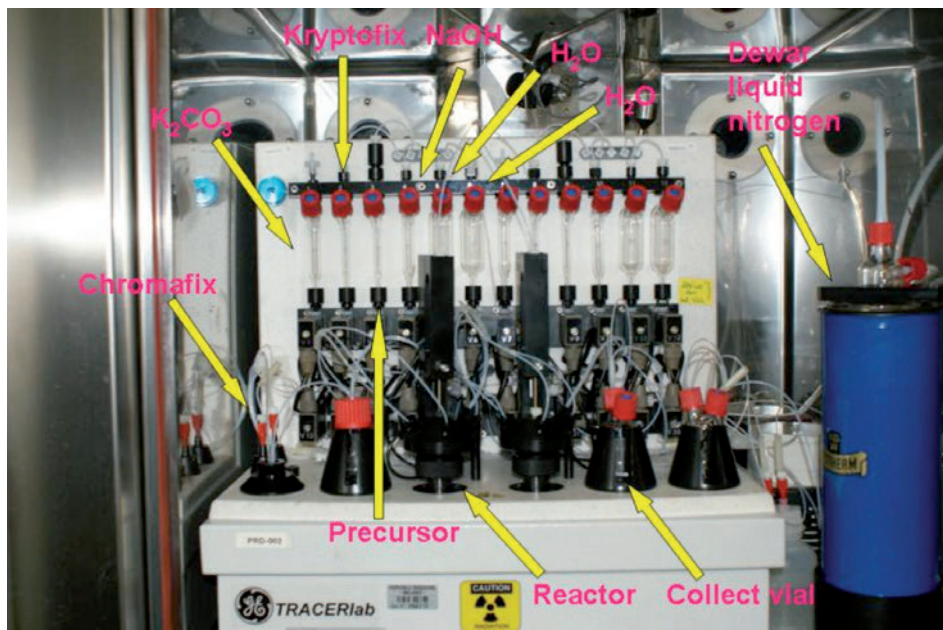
An example of an [ $^{18}\text{F}$ ]FDG double module: TRACERlab FX GE
